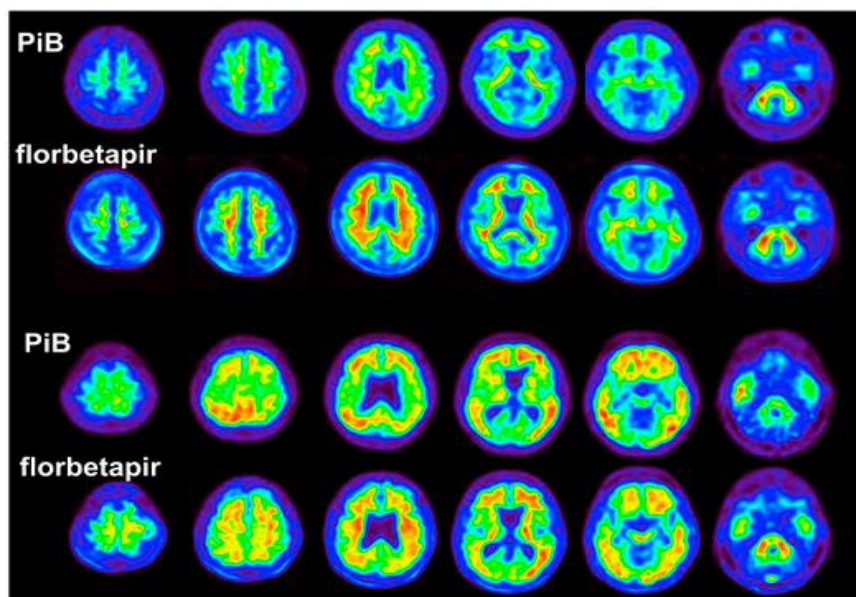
Axial slices of florbetapir and PiB scans of two subjects. A cognitively normal control on the top showing low radiotracer retention and an AD patient on the bottom with high radiotracer retention (SUV_r) [23]
